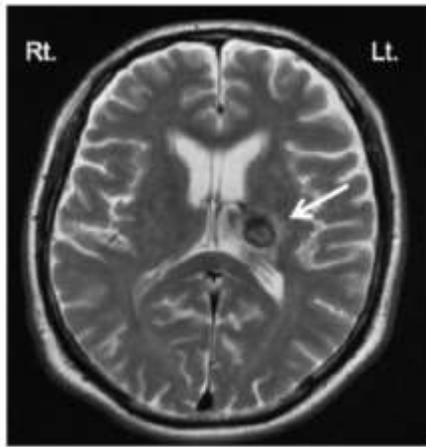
Brain MRI 6 months after tooth extraction
